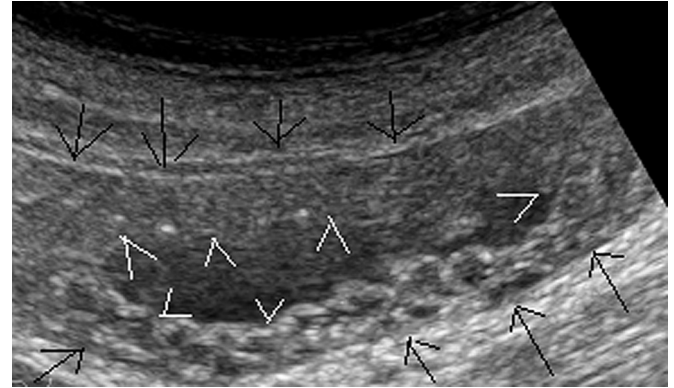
Abdominal sonography shows a longitudinal section of the small intestine. The inner layer and outer layer of the small intestine are indicated by arrowheads and arrows, respectively. Edema change of the small intestine wall is noted.
